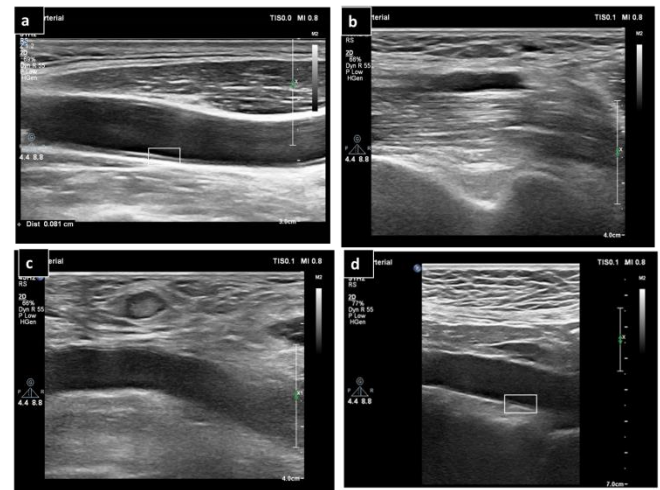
IMT measurements with B-mode ultrasound from different vascular regions a) CC-IMT b) B-IMT c) F-IMT d) A-IMT
